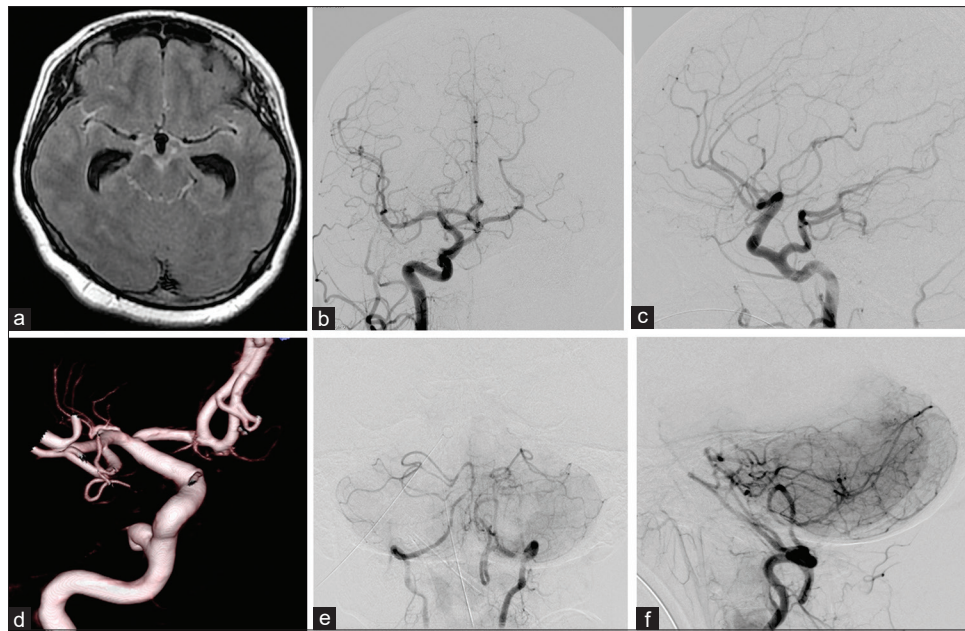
(a) Magnetic resonance imaging shows diffuse subarachnoid hemorrhage. (b-d) Digital subtraction angiography shows no evidence of aneurysm. (e and f) Concomitantly, ipsilateral persistent primitive trigeminal artery is shown with severe hypoplasia of the basilar artery. The section that is proximal to anastomosis with the vertebral artery is very faint
